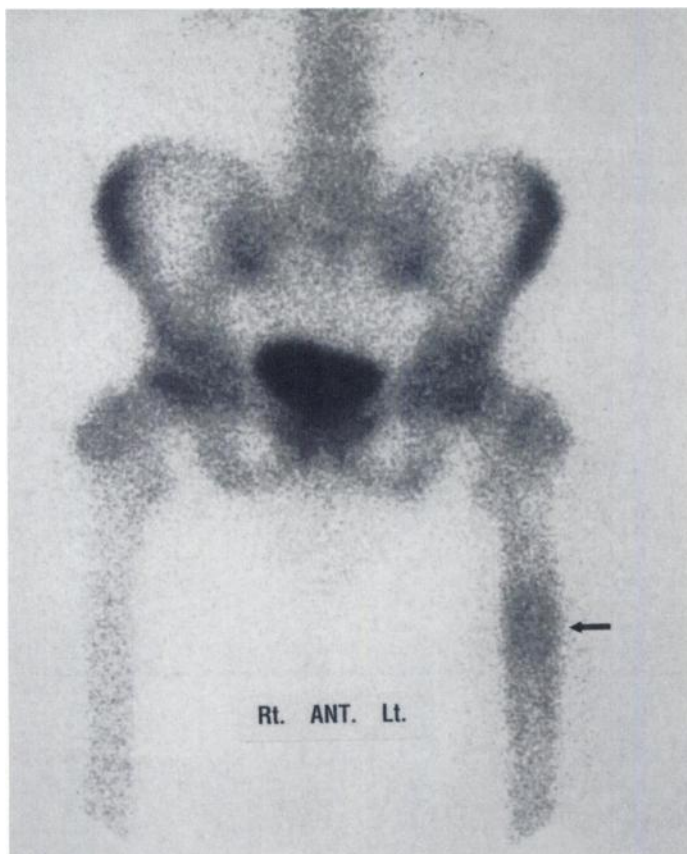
Fifteen-year-old boy with biopsy-proven lesion in the left femur. Bone scintigraphy 1 wk after local radiotherapy (1500 cGy in 5 fractions) showing mild diffusely increased radiotracer uptake in the femoral shaft and hyperemic changes secondary to treatment (arrow).
